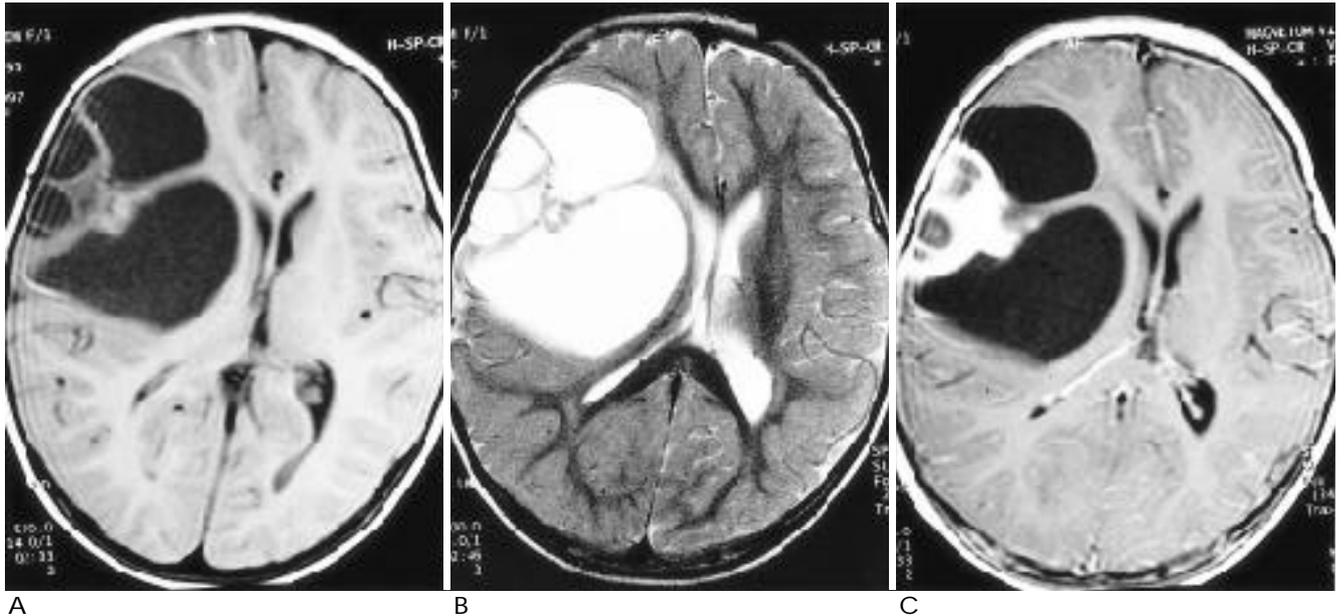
A. T1-weighted axial scan demonstrates about 5 × 7 cm sized multiseptated cystic and solid mass in right superficial frontotemporoparietal area. The solid portion shows iso-intense signal to gray matter, and wall of cystic portion shows slightly high signal intensity.
